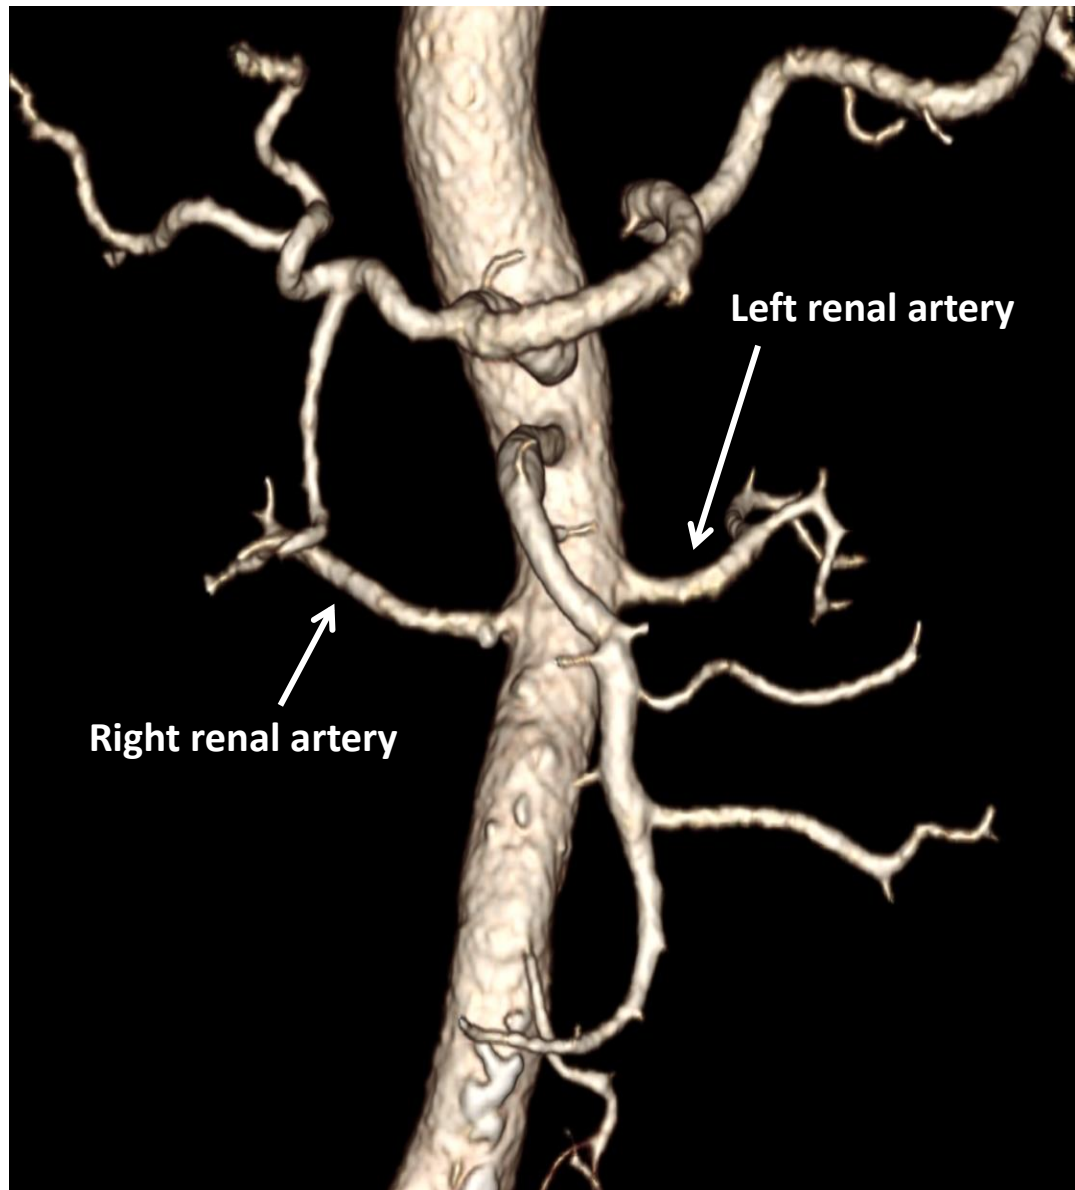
CTA Vasculature of renal artery
